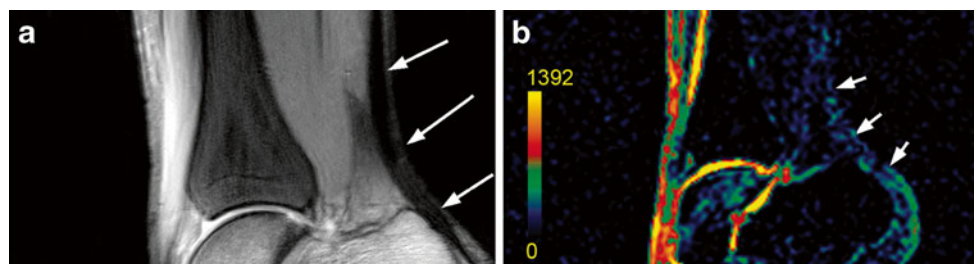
Magnetic resonance images from a 27-year-old healthy volunteer. a Proton-density-weighted turbo spin-echo (TSE) image with *arrows* pointing at the centers of each evaluated region of interest. Parameters: TR/TE 4,000/26 ms; field of view, 140×140 ; slice thickness, 3 mm. Please note that the Achilles tendon thickness and signal intensity are
